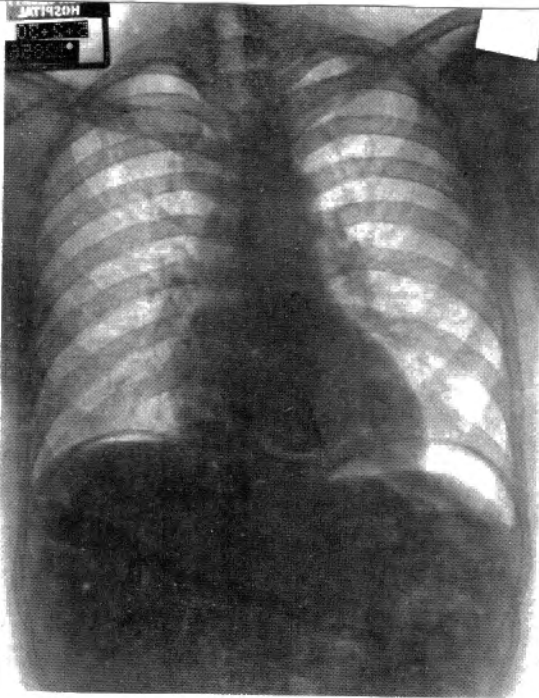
Case 2. Roentgenogram taken 10 hours after acute perforation. The escaped air has collected beneath both domes of the diaphragm. A fluid level is seen below the gas bubble on the right. At operation the perforation was found to be sealed by fibrinous adhesions with the gall bladder.
